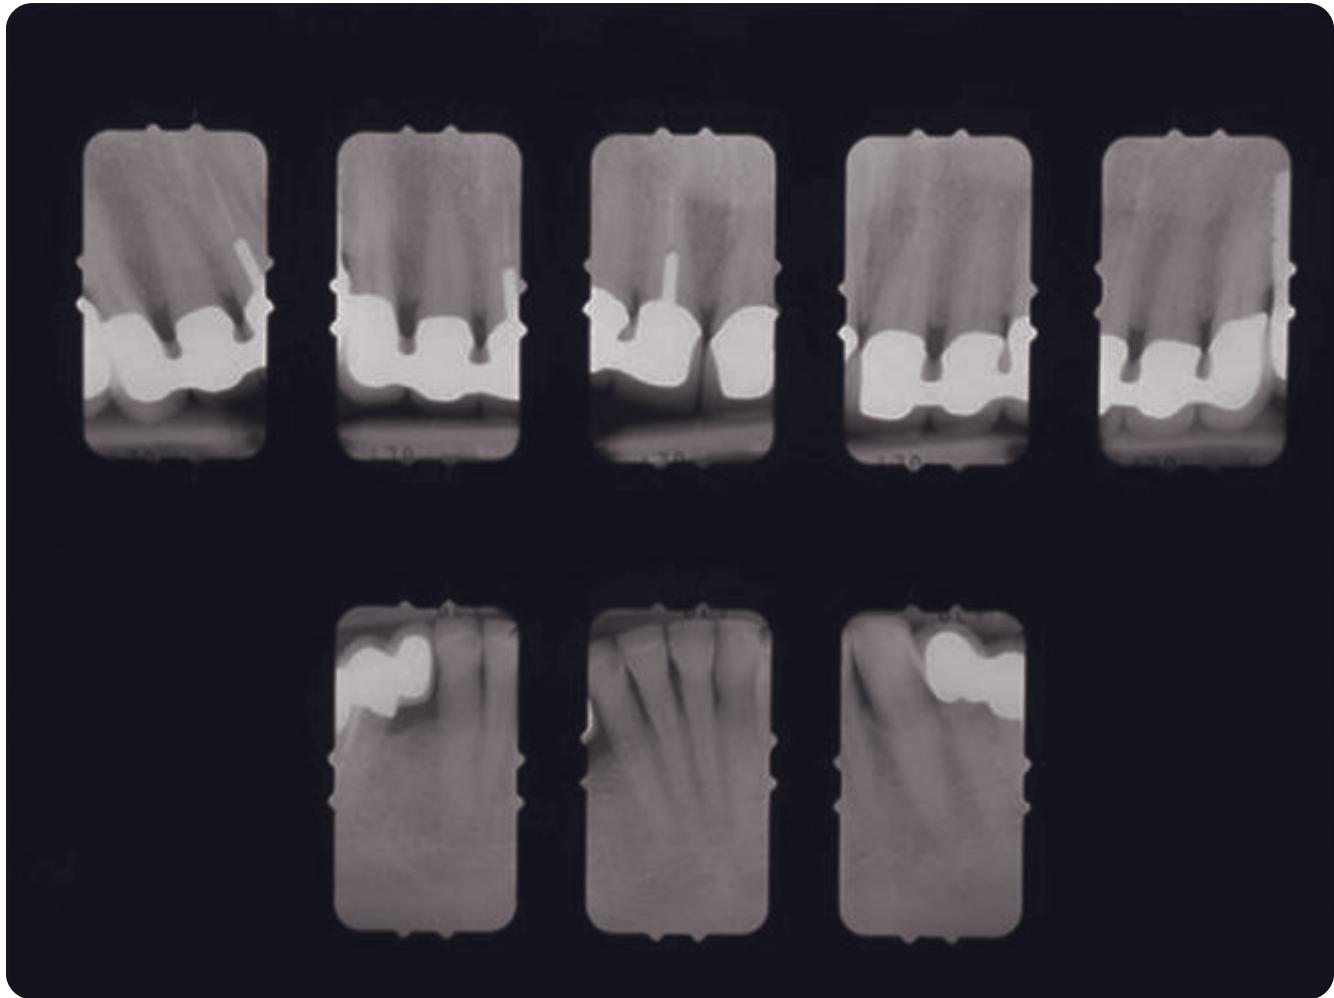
Posttreatment radiographs, anterior.
